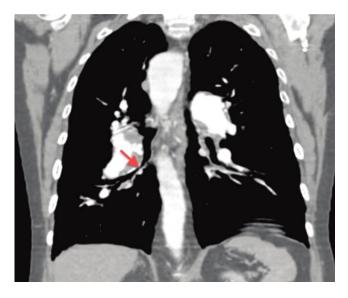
Contrast-enhanced computed tomography reconstructed in the coronal plane of patient B showing right bronchus compression (arrow).
